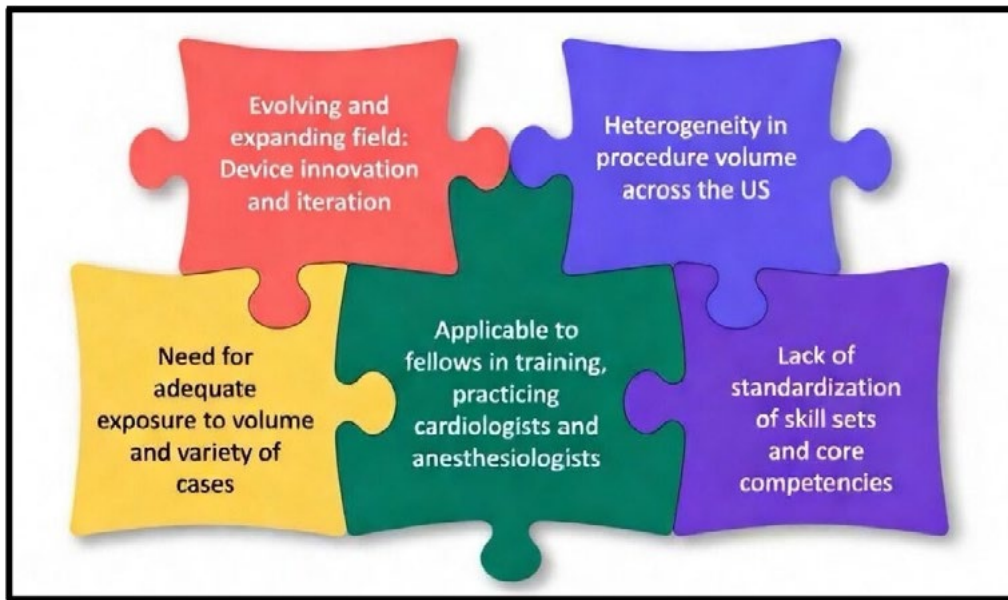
Challenges for Interventional Echocardiography in Achieving and Maintaining Competency.
